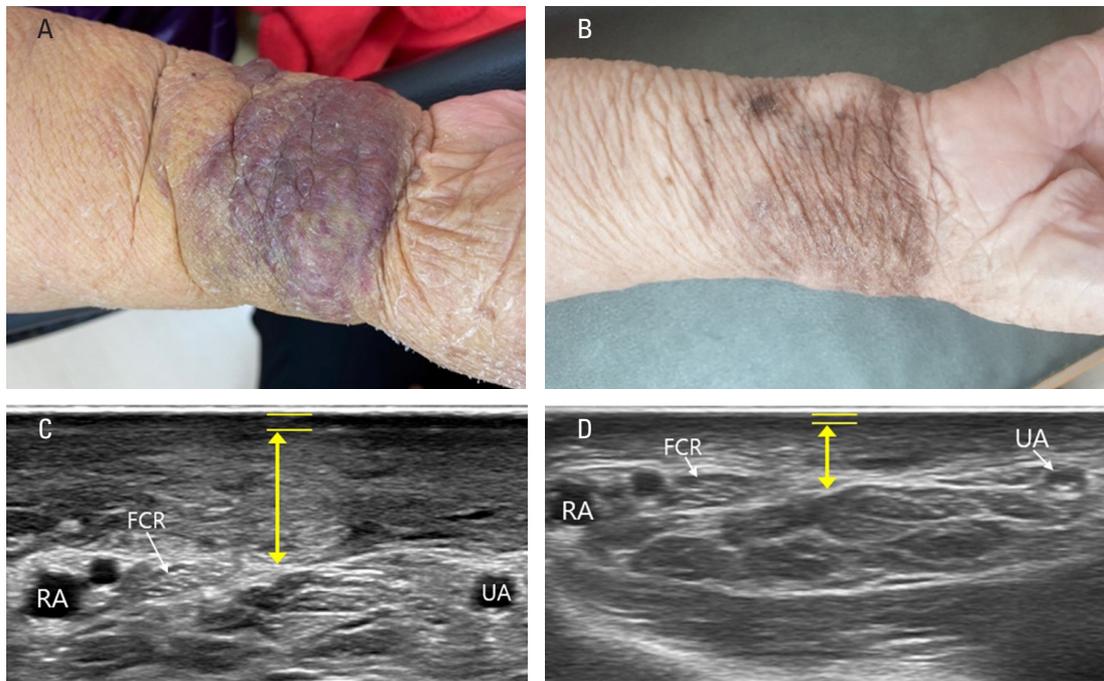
Before and after treatment of pigmented tumor-like lesions in the wrist area. (A) photo of pre-treatment of lesion. Before treatment, non-pitting with trophic skin changes and warty overgrowth corresponding to ISL stage 3 were observed in the wrist, accompanied by purple color change. There were no signs of lymphostatic ulcerations with lymphorrhea or bleeding. (B) photo of post-treatment of lesion. After treatment, only mild pigmentation remained, darkened warty projections disappeared and the original skin texture was restored. (C) ultrasound transverse view of wrist with lesion of pre-treatment. (D) ultrasound transverse view of wrist with lesion of post-treatment. Yellow arrows in C and D indicate the thickness of the subcutaneous tissue corresponding to the region of interest in lymphedema (between the skin and fascia); The yellow parallel lines indicate the thickness of the skin layer. A decrease in subcutaneous layer thickness is seen along with the skin layer thickness, which is a characteristic finding in lymphedema.⁹ RA: Radial Artery, UA: Ulnar Artery, FCR: Flexor Carpi Radialis tendon
